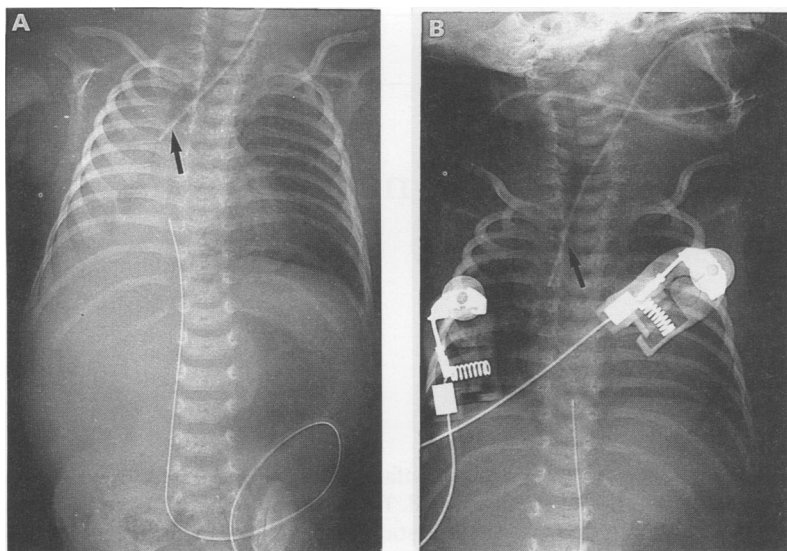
(A) Chest radiograph of the baby with the most severe stenosis of the right main bronchus. Stenosis reappeared immediately after each balloon catheter dilation, so that the inflated balloon catheter was left in place during 24 hours (arrow). Intermittent injection of oxygen or air through the central channel across the balloon prevented pulmonary collapse. (B) After 24 hours the ventilation of the right lung was permanently restored and the catheter could be removed.
